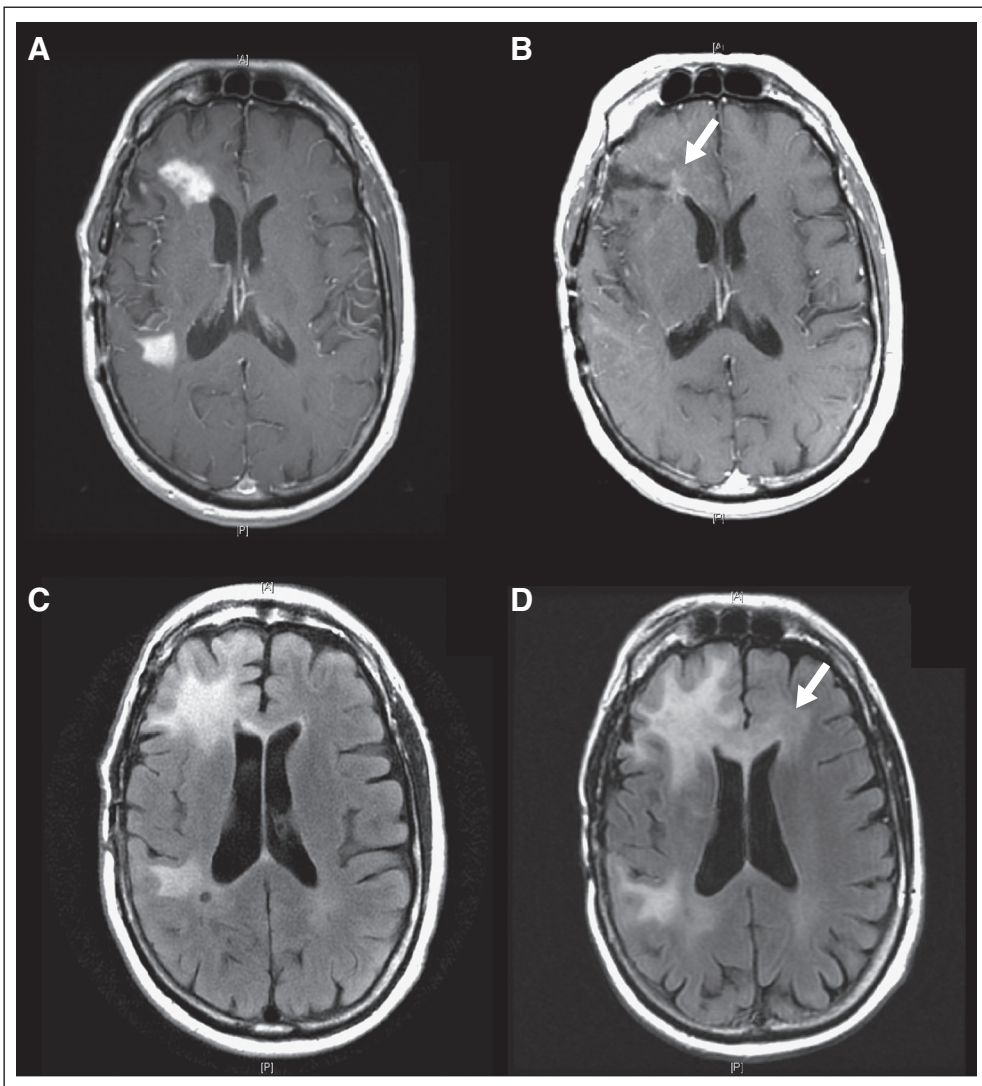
A 54-year-old patient with recurrent glioblastoma showing nonenhancing progression after bevacizumab therapy. Axial contrast-enhanced, T1-weighted images show (A) scan at recurrence showing multifocal right frontal glioblastoma; (B) decreased enhancement after 7 months of therapy that qualifies by Macdonald Criteria as partial response; (C) axial fluid-attenuated inversion recovery image at baseline and (D) after 7 months of therapy showing nonenhancing tumor progressing through corpus callosum to the left frontal lobe.
